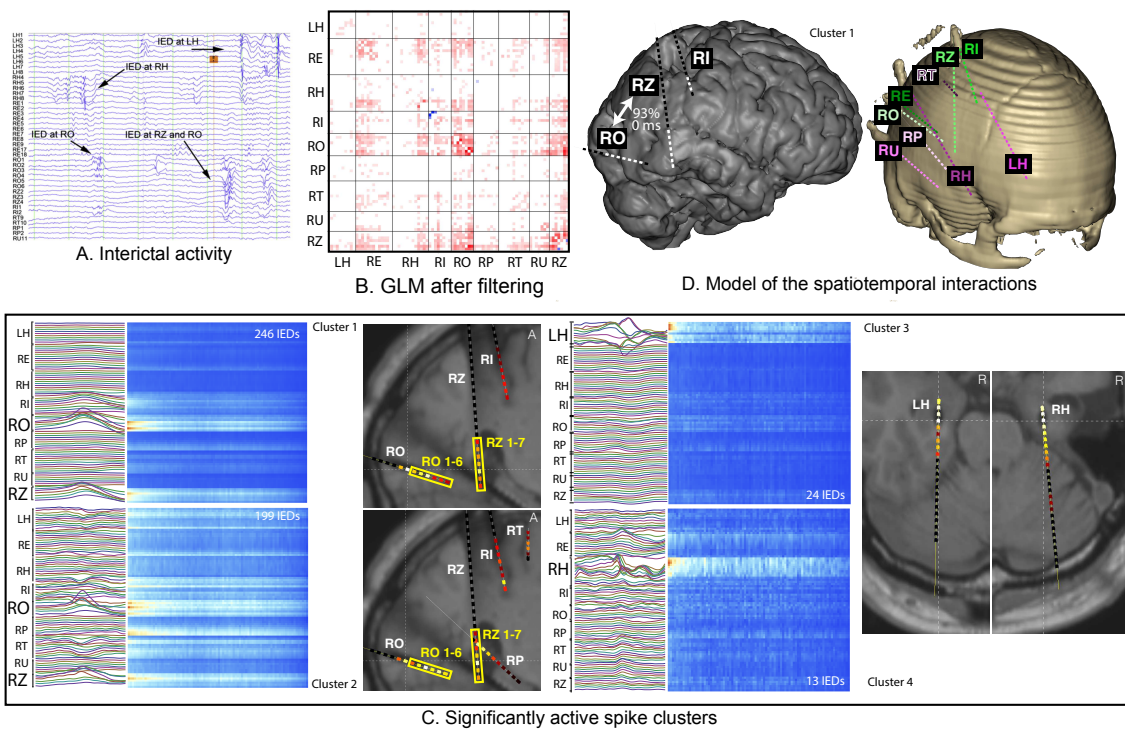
Results of the SEEG analysis for patient 5. A) The SEEG recording showing IEDs at the depth electrodes. B) The output of the General Linear Model indicating that most of the SEEG signals are significantly involved in the epileptic discharges. C) The spatiotemporal distribution of the distinct spike clusters involved. At the left, the spike clusters are shown with maximal activity at electrodes RO and RZ. The overlap with the SOZ is indicated by the yellow boxes. At the right, the spike clusters with maximal activity at, respectively, the electrodes targeting the left (LH) and right (RH) hippocampus. D) The model of the network organization which shows the depth electrodes that are part of the epileptic network (left). The association strength ratios are denoted in percentages and the estimated delays are given in milliseconds. The implanted depth electrodes are shown together with the CT-scan at the right.
